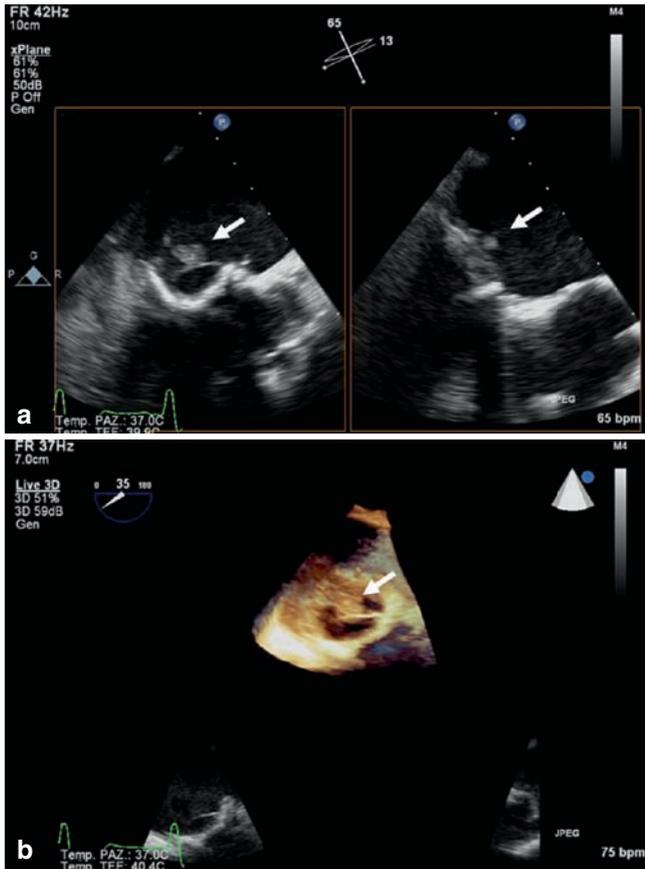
Real-time 3D trans-oesophageal echocardiography showing a small vegetation attached to the leaflet of a bioprosthetic valve in the mitral position. Multi-plane visualization of the vegetation (white arrows), (a). Rendering display of the vegetation allows better assessment of the size and shape of the vegetation (white arrow), (b)
